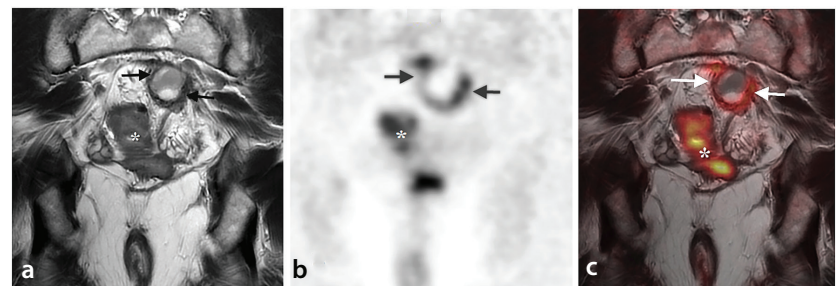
Postsurgical fat necrosis in a patient with operated rectal cancer arising from ulcerative colitis. The coronal T2-weighted magnetic resonance image (MRI) (a) shows a presacral lesion with central hyperintensity and a hypointense fibrous capsule (arrows) (the "doughnut sign"). The coronal positron emission tomography (PET) (b) and coronal fused PET/MRI (c) reveal peripheral fluorodeoxyglucose (FDG) uptake. There was no progression on follow-up. Note also that the asterisks in images (a-c) mark FDG-avid bowel segments with ulcerative colitis.
